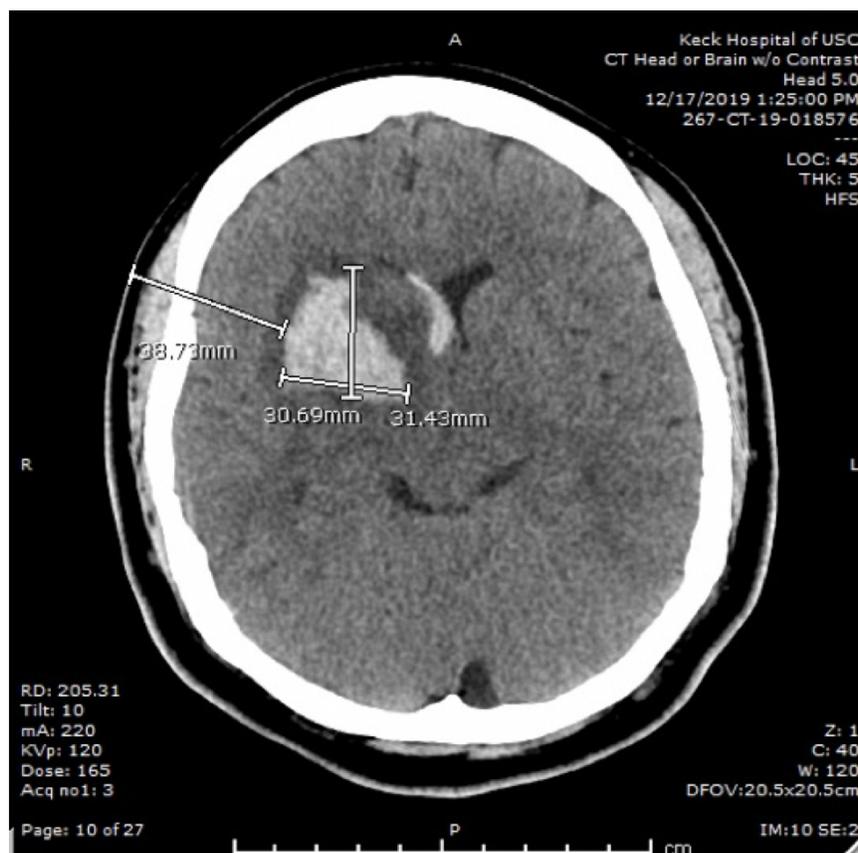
Axial representation of hemorrhagic stroke on noncontrast CT imaging
